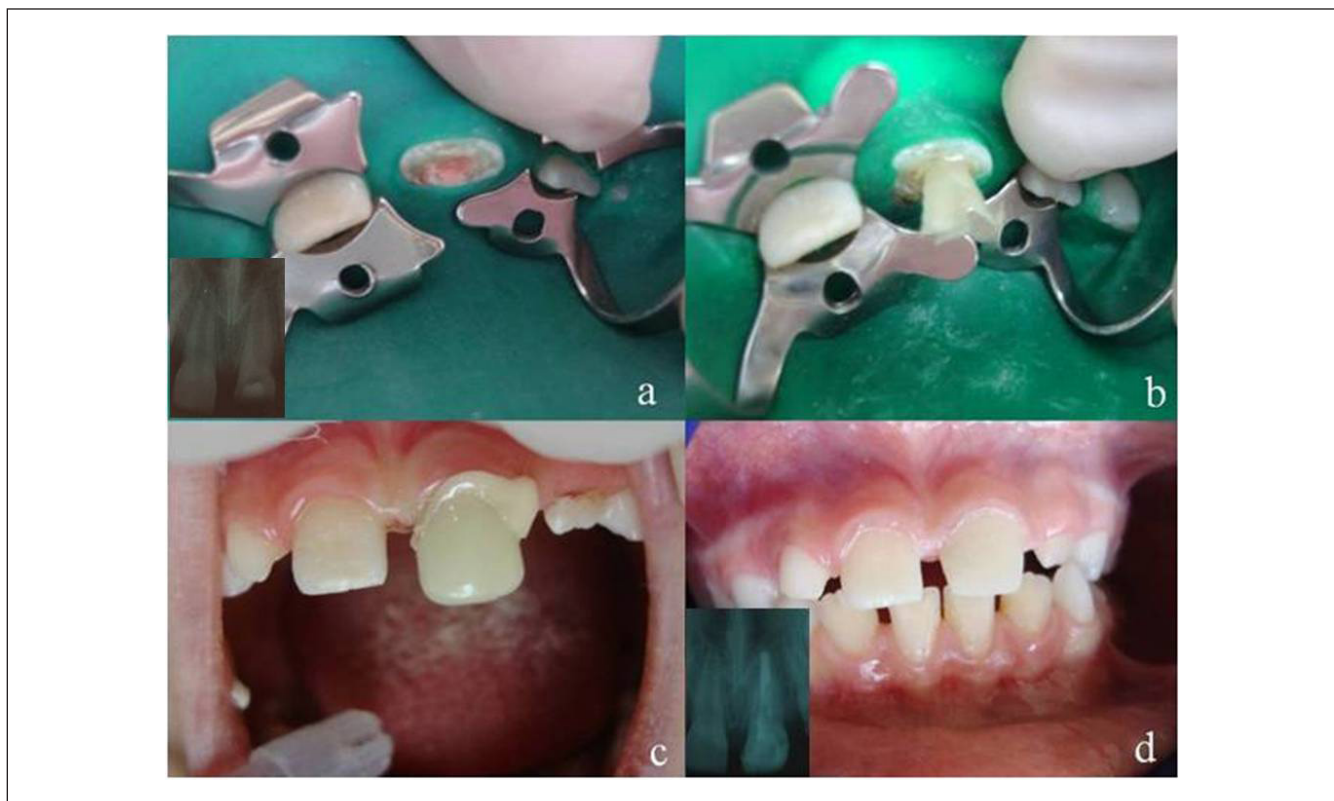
The treatment procedures used in the second case. a. Periapical radiograph revealed a complicated crown root fracture of the maxillary left central incisor and the root canal was obturated with thermoplasticized gutta percha. b. Ribbond was inserted into the canal. c. The tooth was restored with strip crown. d. Clinical and radiographic appearance after treatment.
